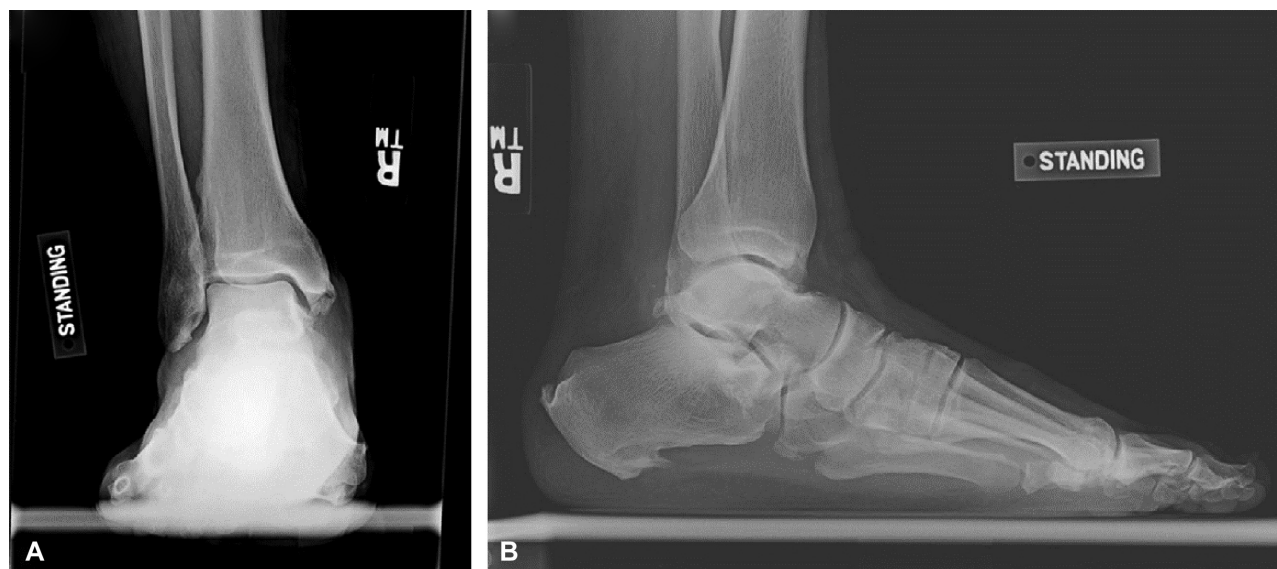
(A) Standing anteroposterior; (B) lateral radiographs of right ankle demonstrating no evidence of calcification within the mass.
